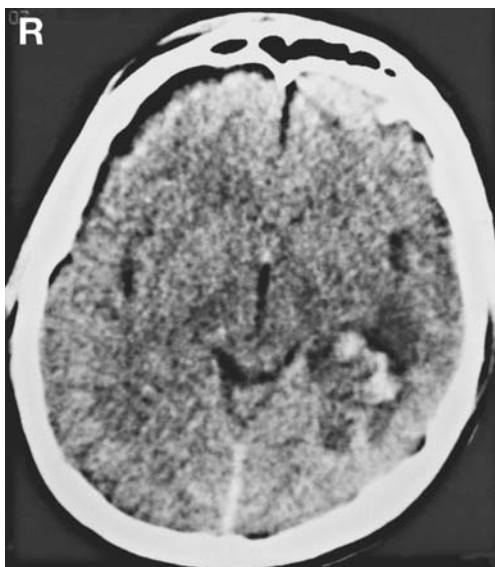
Computed tomography scan taken soon after the trauma showing a heterogeneous hyperdense area in the left temporoparietal region indicating posttraumatic intracerebral hemorrhage.
